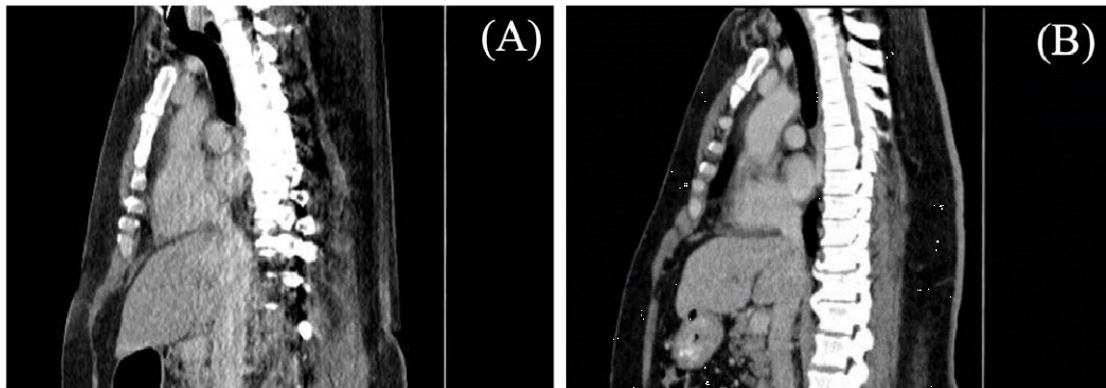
(A) Sagittal CT following intubation with significant posterior deviation of the mid to lower trachea. (B) Comparison CT from 2 months prior to this case presentation demonstrates normal tracheal alignment without A-P deviation.
